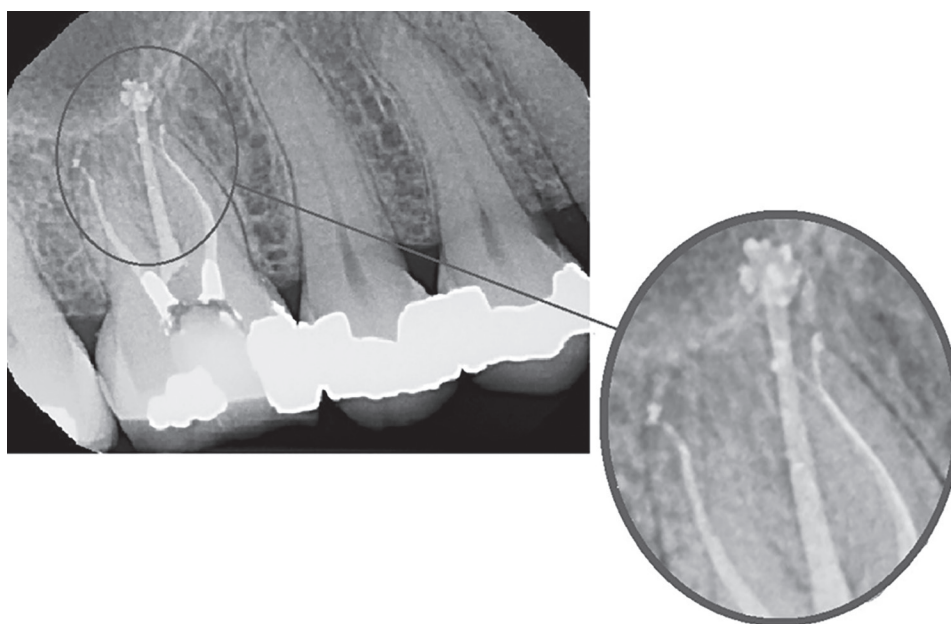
Postoperative periapical radiography highlighting complex apical anatomy
